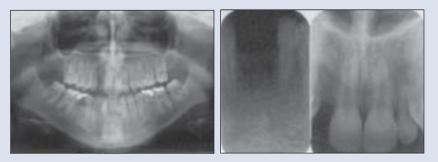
Radiographic views following debonding: orthopantomographic view and periapical views of incisor area.
